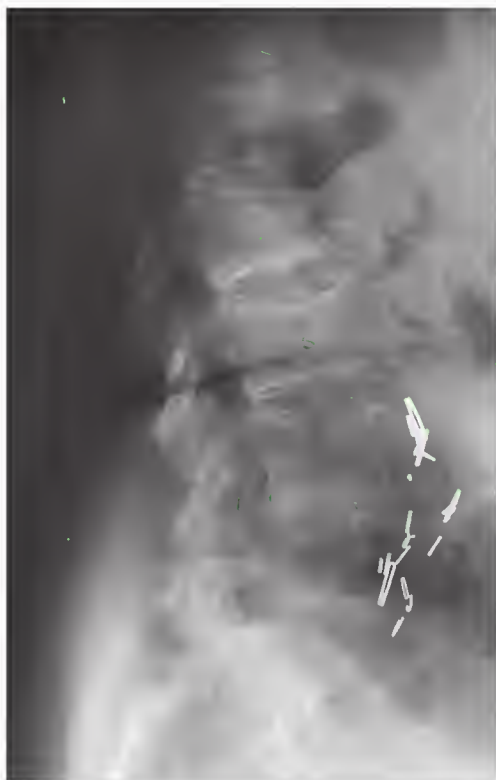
Osteoporosis. A plain radiograph, lateral view, demonstrates diffuse osteopenia and multiple compression fractures.
